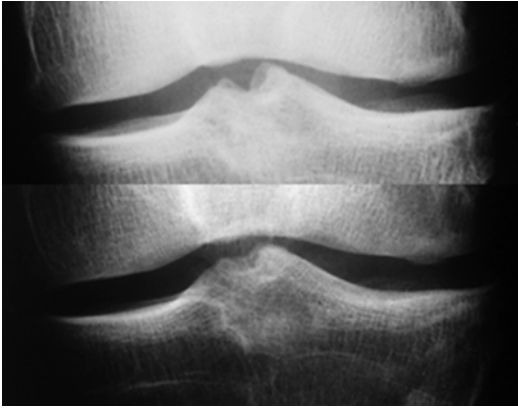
Top and bottom: standing X-rays after lateral meniscal transplantation 10 years after the index surgery. No lateral joint narrowing is seen 10 years after lateral MAT
